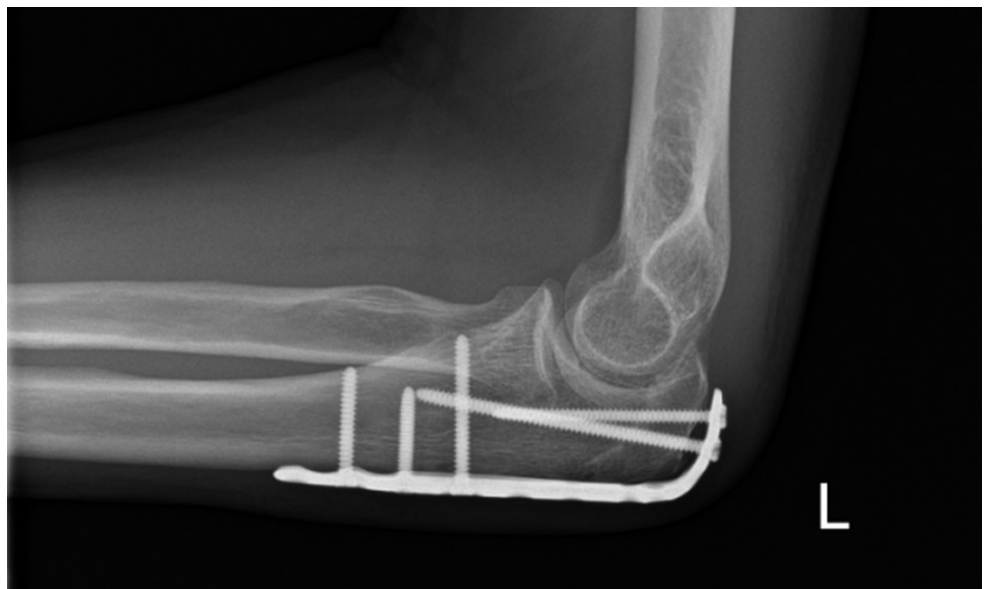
Lateral plain X-ray of open reduction internal fixation using locking plate.
